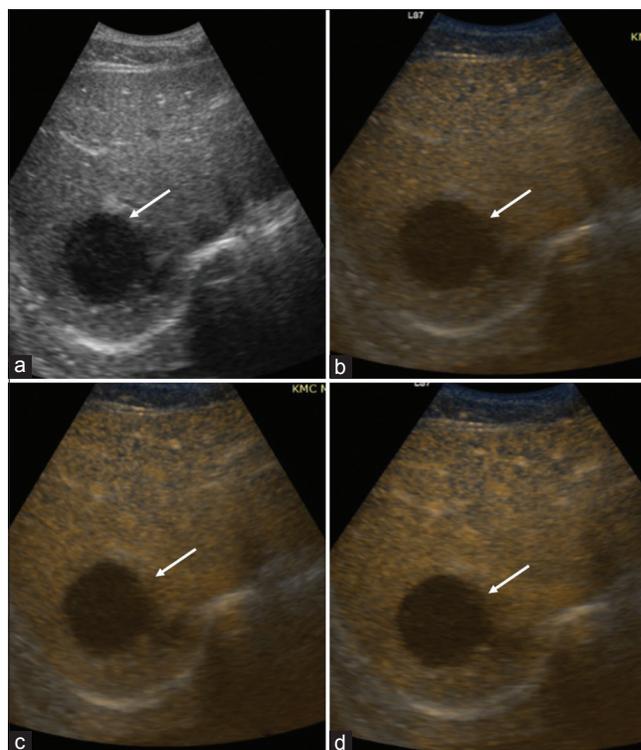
A 25-year-old male patient presented with fever and right upper quadrant pain. Ultrasound showing hypoechoic lesion in the liver (white arrow, a). Contrast-enhanced ultrasound of the same lesion showing no enhancement of the lesion at 25 s (white arrow, b) after contrast injection (arterial phase). Contrast-enhanced ultrasound of the same lesion showing mild peripheral enhancement at 85 and 160 s (white arrow, c and d) (portovenous and delayed phases) suggesting abscess. Later, the diagnosis is confirmed by aspiration and culture showing growth of *Klebsiella*
